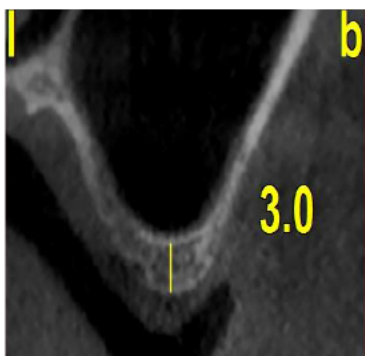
Measuring residual ridge height in CBCT cross-sectional image.
